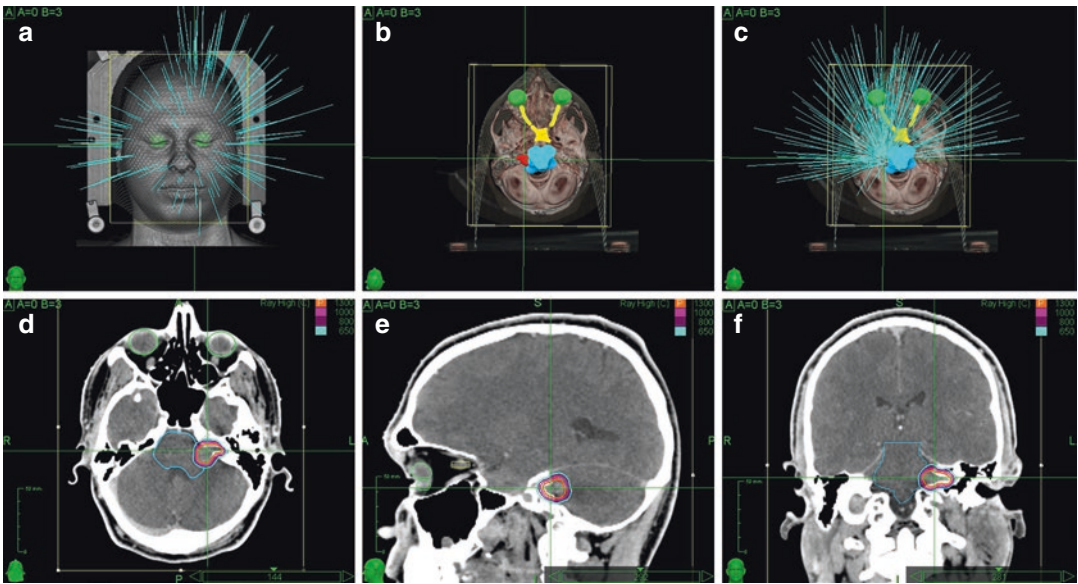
(a–c) A three-dimensional representation of a patient model created by the treatment planning system using the volumetric CT scan of the patient. (d–f) Axial, sagittal, and coronal two-dimensional representations of the patient anatomy generated from the acquired CT scan.
